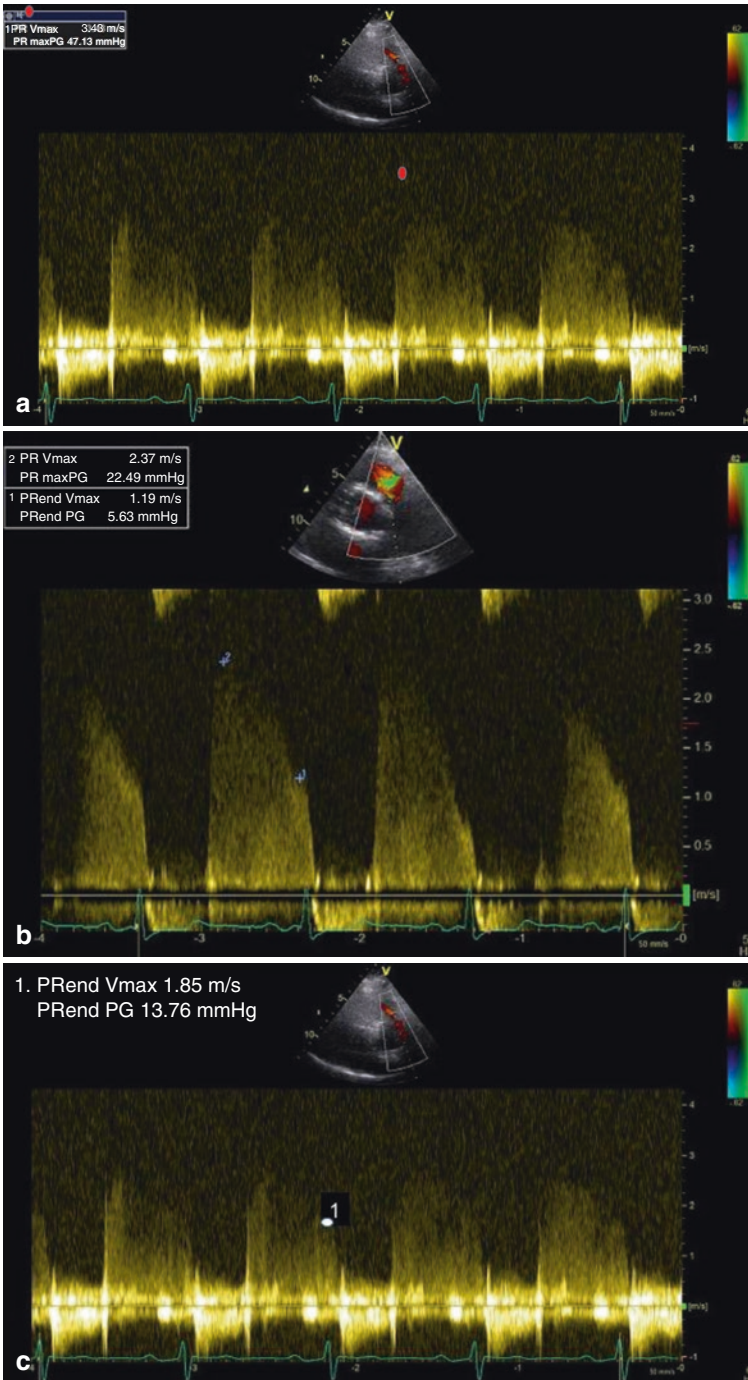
(a) Continuous wave Doppler of the pulmonary valve regurgitation. (b) Shows another example of maximal regurgitation velocity and end diastolic regurgitation velocity. (c) End-diastolic velocity of pulmonary regurgitation
